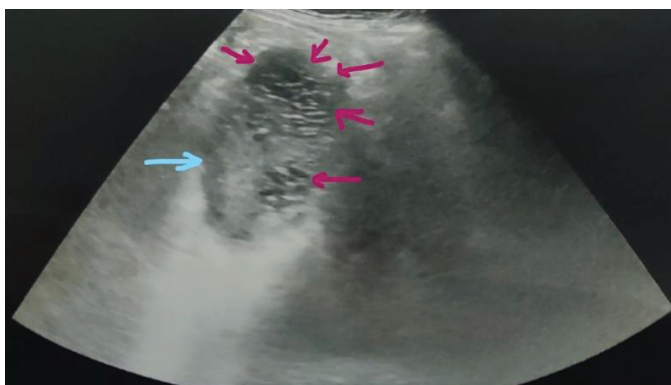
Point-of-Care Ultrasound (POCUS) of the abdomen showing an inhomogeneous spleen.
